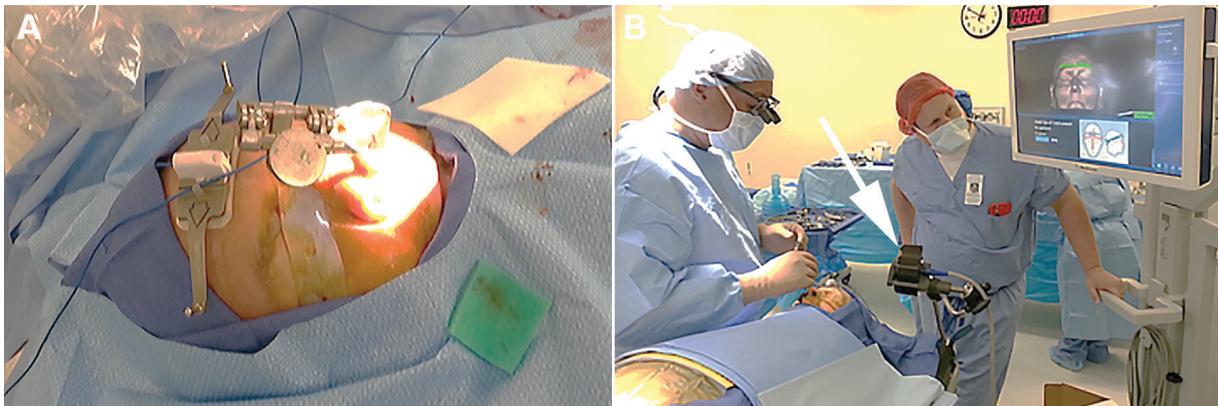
Operative setting for transsphenoidal combined microsurgical and endoscopic approach. (A) The patient tracker is placed on the forehead. (B) The AxiEM magnetic field emitter (white arrow) was fixed on the side of the surgical table directly and adjacent to the head of patient to obtain a stable magnetic field covering the head. The patient is registered according to MRI images, which are loaded into the system.
